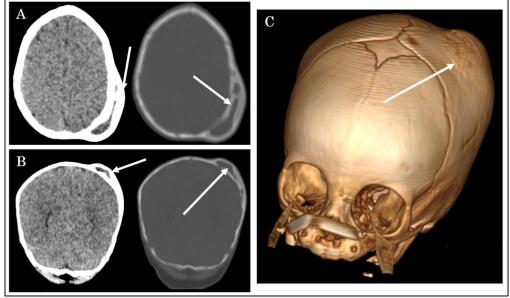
A CT-scan in axial (A) and coronal (B) views with 3D reconstruction (C) a left parietal extra-cranial hypodense collection, unenhanced after contrast administration. The collection was enclosed between two bony plates, with the external layer continuous with the calvarium, producing the characteristic "double skull sign".
